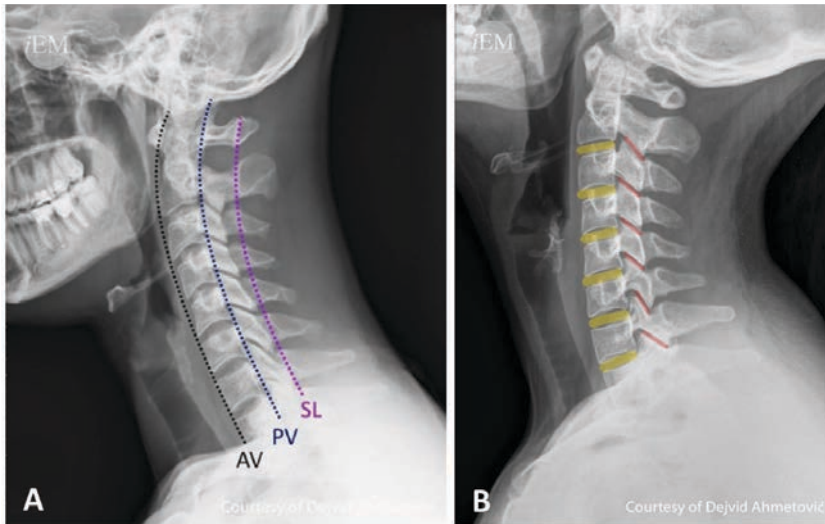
Cervical Spine X-ray. (A) Anterior vertebral (AV), posterior vertebral (PV) and spinolaminar lines (SL). (B) intervertebral cartilage spaces¹⁷³
